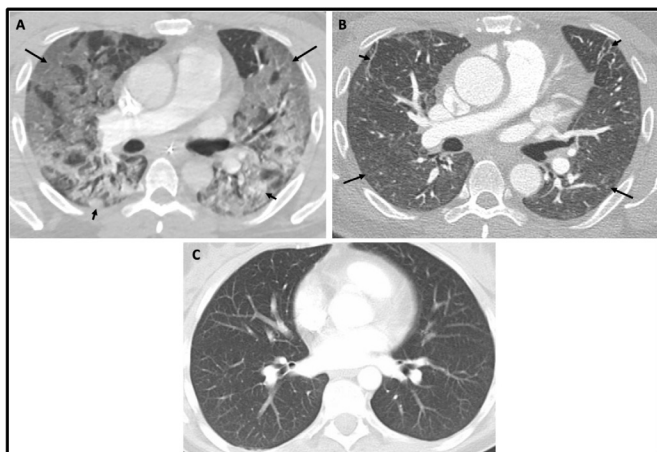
Chest CT in severe COVID-19. Typical COVID-19 appearance with ground glass opacification (long arrow) and peripheral basal consolidation (short arrow) on during hospital admission (A) and 4 months later (B) with residual atelectasis (short arrow) and subtle ground glass opacification (long arrow) in a patient with severe COVID-19 with ongoing symptoms compared with a patient with COVID-19 without symptoms (C).
